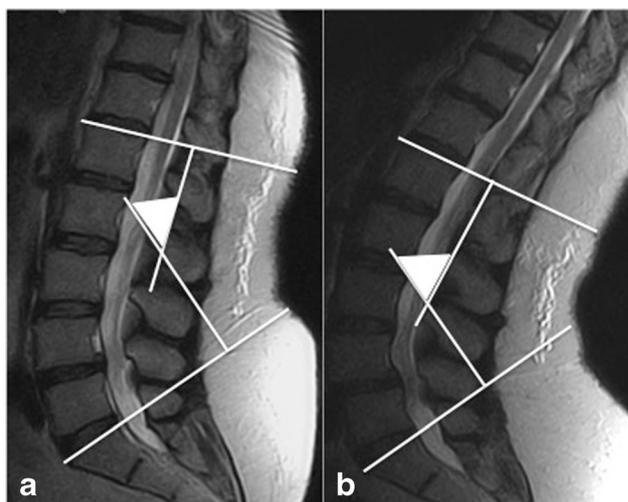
Sagittal T2-weighted TSE in supine (a) and upright (b) standing. Lordotic angle is measured according to Cobb's method, increased in b
